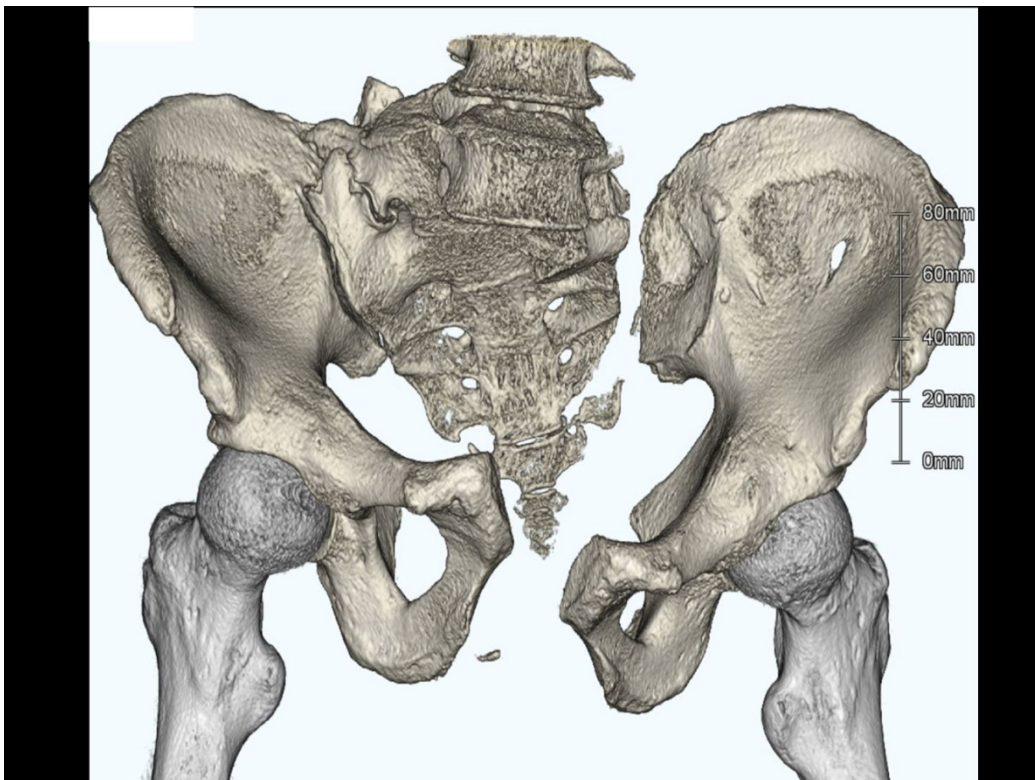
Three-dimensional computed tomography (CT) on arrival. CT revealed complete L5/6 dislocation fracture and vertical shear pelvic ring unstable fracture.
